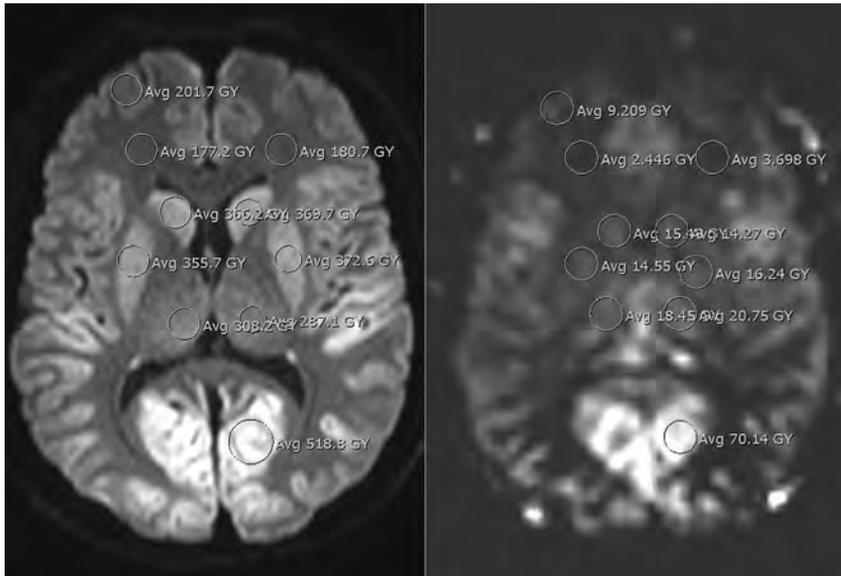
Sample image showing 10 of the 12 ROI measurements on DWI (*left*) and ASL (*right*) at the level of the basal ganglia in a patient who had anoxic brain injury.
